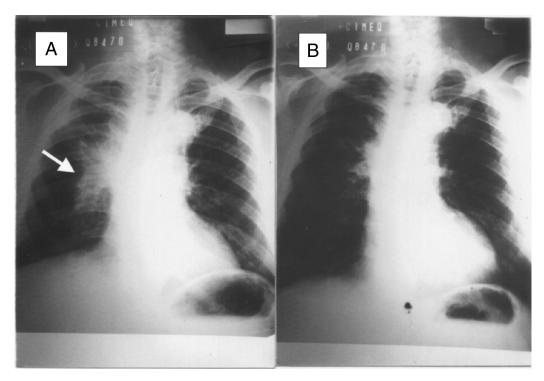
Chest X-ray of a stage IV non-small-cell lung cancer patient: (A) before EGF vaccination; (B) 12 months after EGF vaccination.
